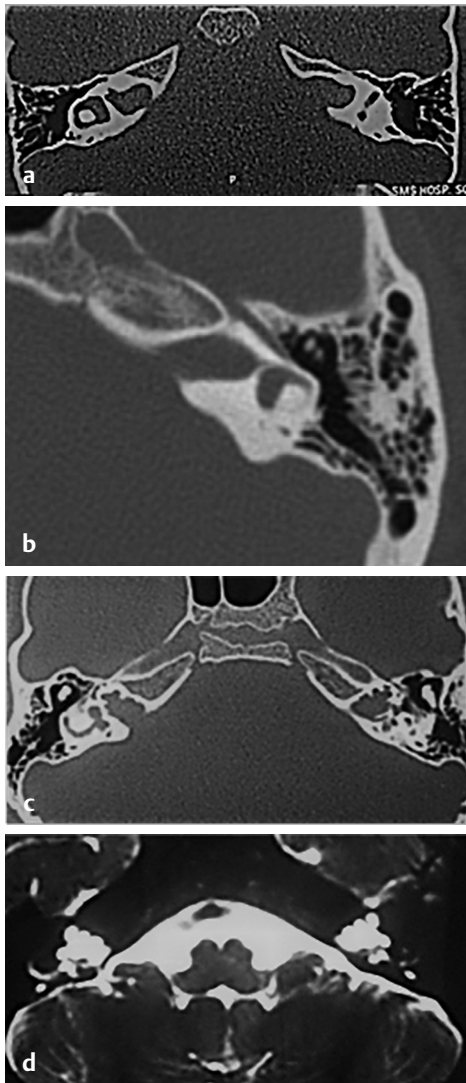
(a, b) HRCT temporal bone, bone window, axial sections show dilated internal acoustic canal (IAC) with cochlear aplasia; and (c) HRCT temporal bone, bone window; and (d) MRI CISS sequence axial sections show widened IAC in SMS CVM type 3.
